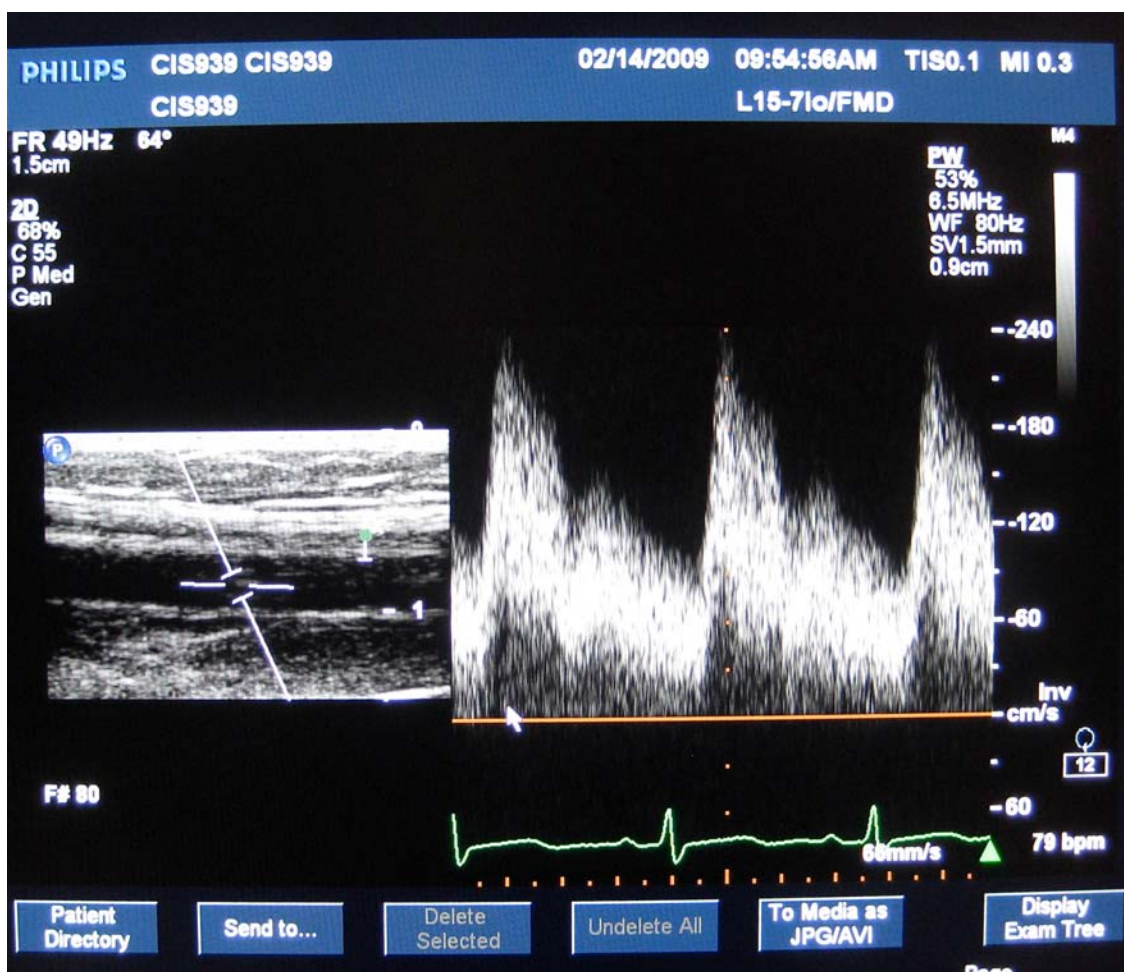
Brachial artery diameter and Doppler velocity upon release of the forearm cuff.
